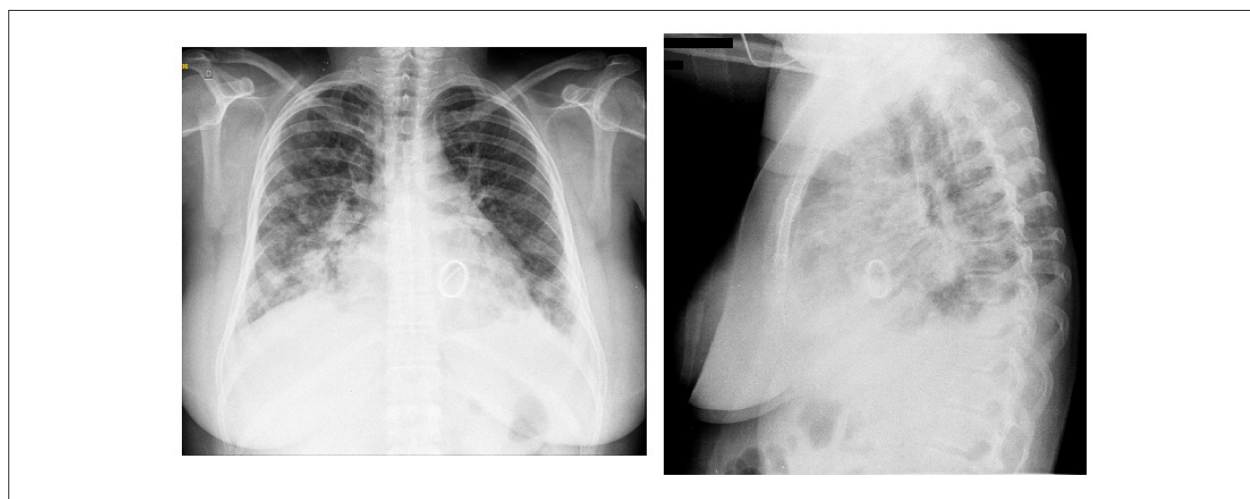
Admission chest x-ray: signs of congestion and pulmonary infection (air bronchogram).
